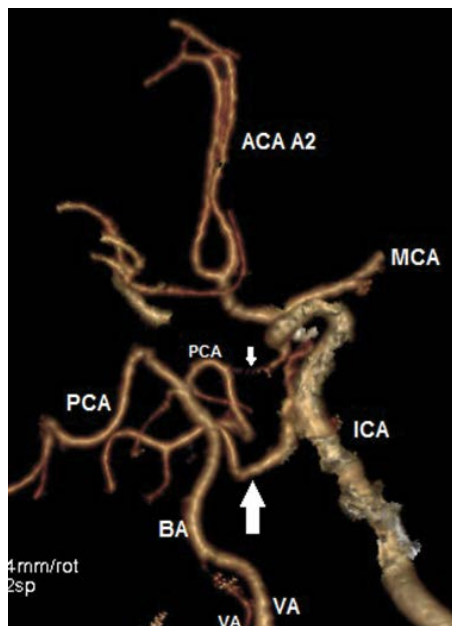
Volume rendering three-dimensional reconstruction, cerebral angiogram based on computed tomography angiogram examination. Bigger arrow persistent trigeminal artery (connection basilar artery [BA]-internal carotid artery [ICA]), smaller arrow posterior communicating artery (connection posterior communicating artery [PCA]-internal carotid artery [ICA]), both on left side; ACA — anterior cerebral artery; MCA — middle cerebral artery; VA — vertebral artery.
